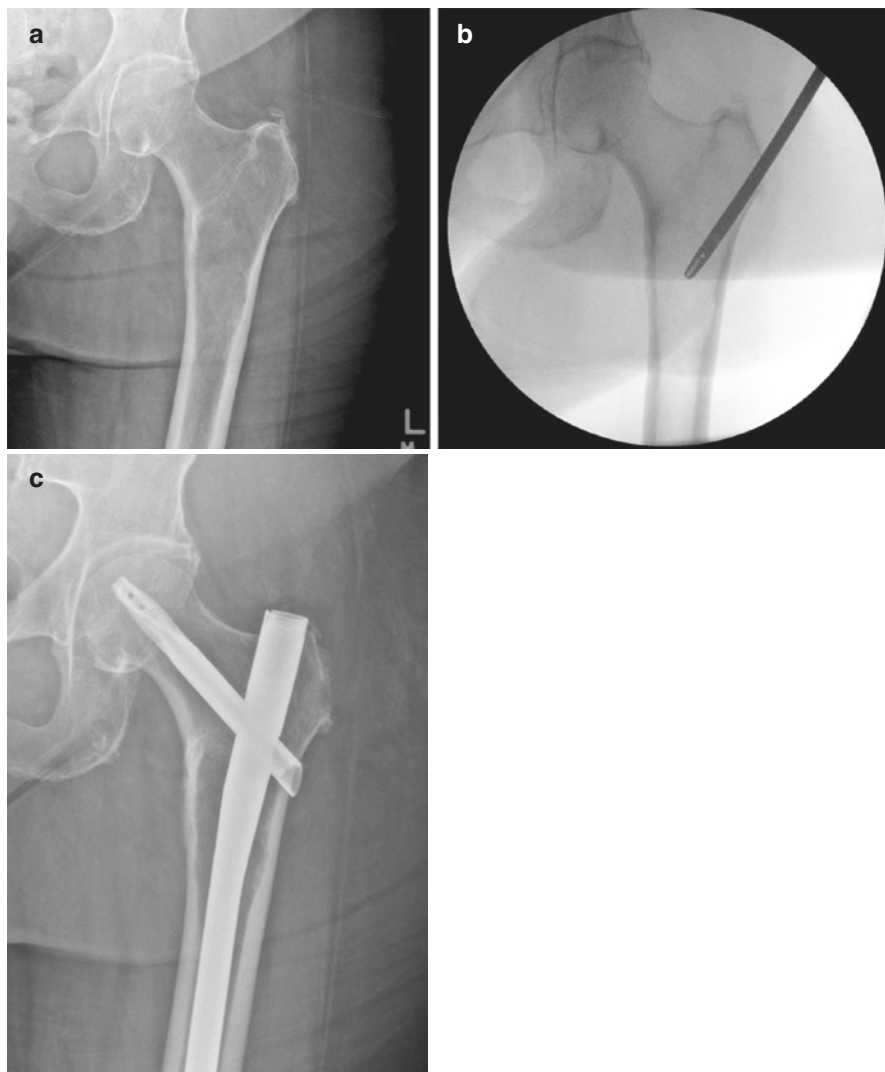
(a) Preoperative AP radiograph of an impending pathologic fracture through a lesion in the subtrochanteric region (ultimately found to be B-cell lymphoma). In order to avoid a stress rise in a vulnerable area, a (b) trans-trochanteric biopsy of the lesion was performed prior to (c) prophylactic long cephalomedullary nail fixation
